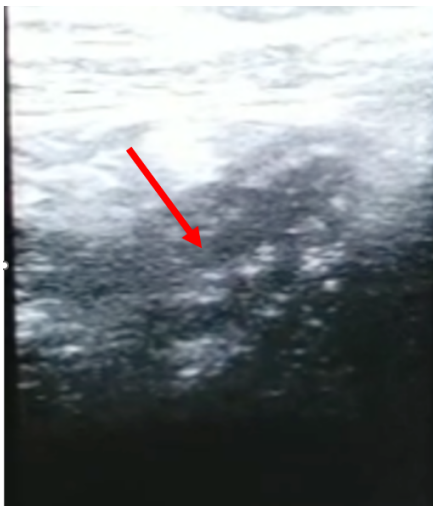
Abdominal ultrasound showing (red arrow) the appendicular stump with a diameter of 10mm and a length of 23 mm.
